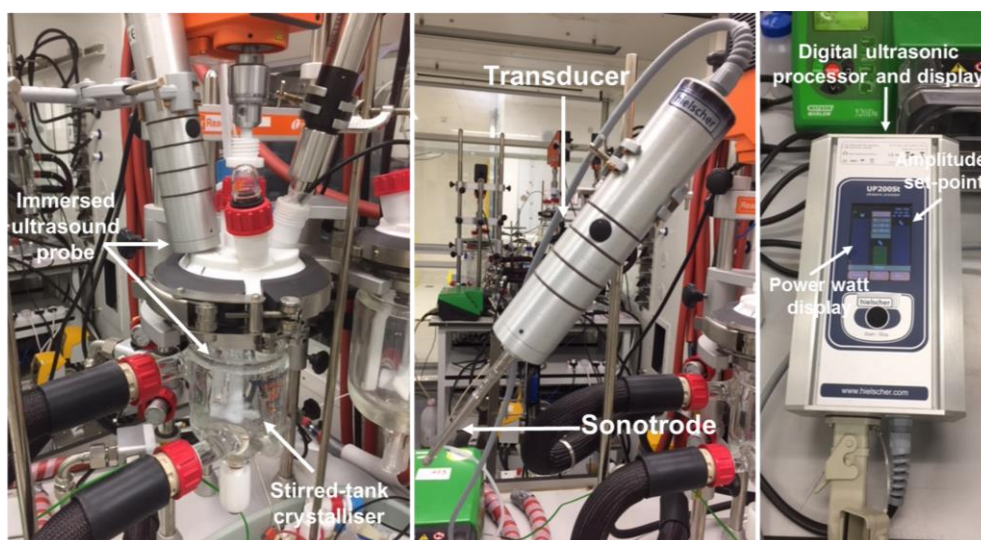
Laboratory setup of batch crystallisation integrated with an immersed ultrasound probe horn in direct contact with a liquid solution. The ultrasound device displayed is an UP200St (Hielscher, 200W 26kHz) probe.
